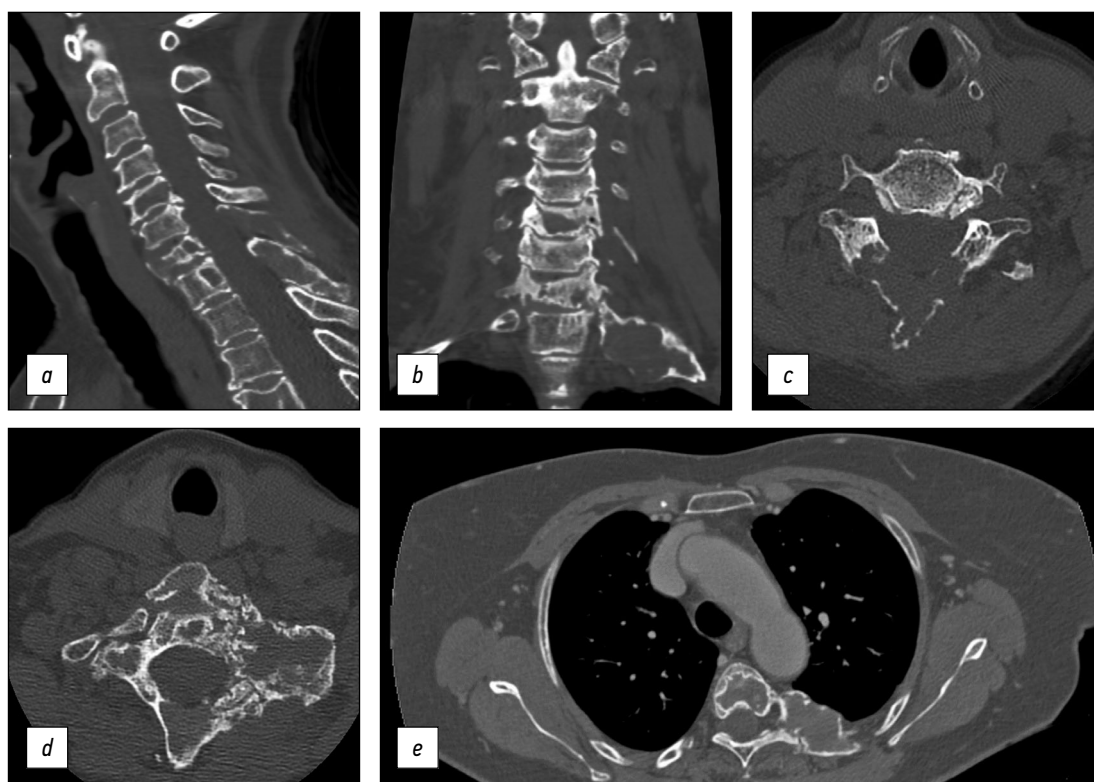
Sagittal (a) and coronal (b) cervical CT showing extensive lytic bone lesions at C5, C7, and D1 vertebrae, involving the seventh cervical posterior laminae and spinous process (c). The posterior arch of the first left rib shows an expansile bone lesion, surrounded by a thin and blown cortical layer, with a ground-glass bone matrix appearance and no soft tissue component (better seen on the axial plane in the figure 2d). Axial plane of the thoracic CT scan showing the involvement of the fifth dorsal vertebra, together with the corresponding left rib (e).
